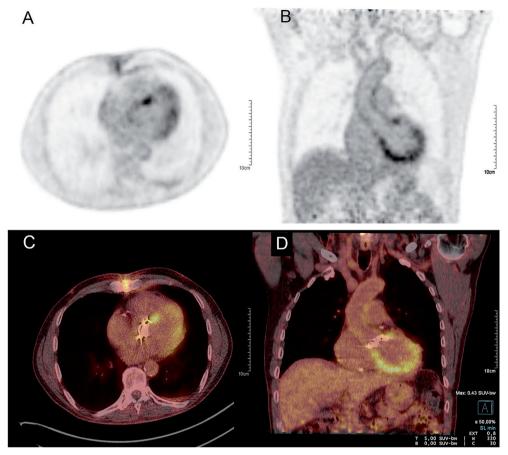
Attenuation-corrected ¹⁸F-FDG PET images (A,B) and fused images (C,D) of a patient with a high level of myocardial ¹⁸F-FDG uptake making correct measurements of the SUV values more difficult.
